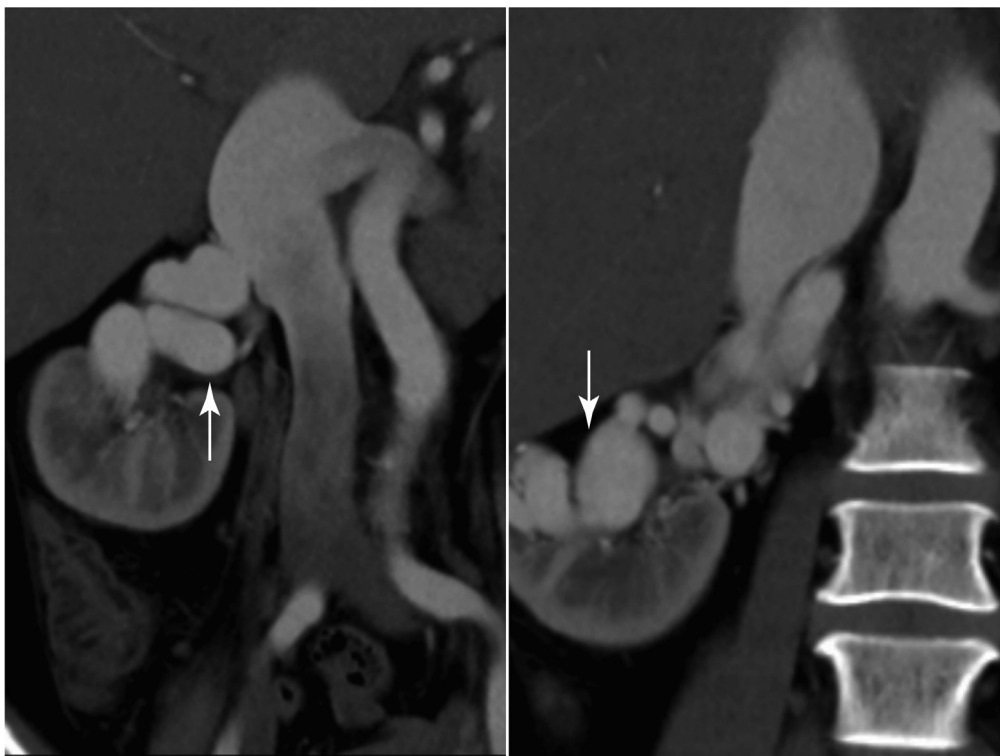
Coronal computed tomography angiography image showing a large tortuous right renal arteriovenous fistula (AVF; arrow) with engorged inferior vena cava.
